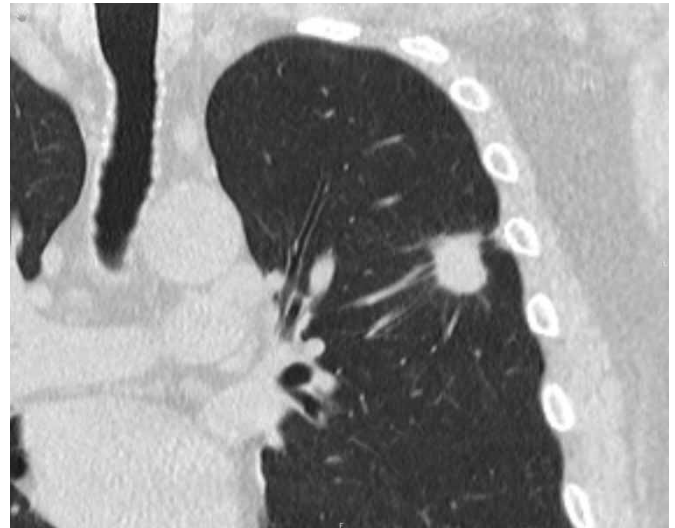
Chest computed tomography scan, coronal reconstruction: non-calcified spiculated nodule with pleural tags.
